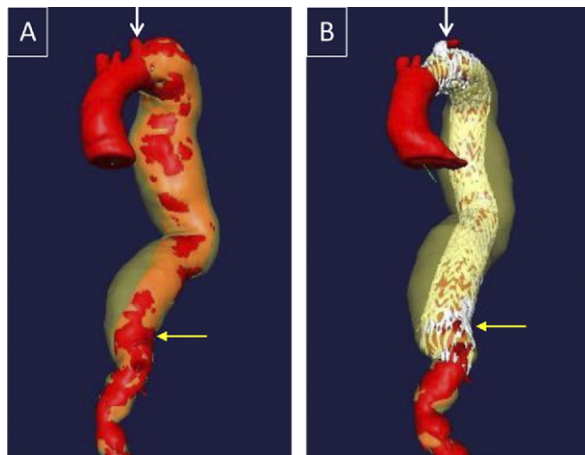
Three-dimensional reconstructions of a computed tomography angiogram using M2S software (West Lebanon, NH) show an extent I thoracoabdominal aortic aneurysm (A) preoperatively and (B) after thoracic endovascular aneurysm repair. Note the landing zone extension to include coverage of the left subclavian artery (*white arrow*) proximally and the celiac artery (*yellow arrow*) distally.
